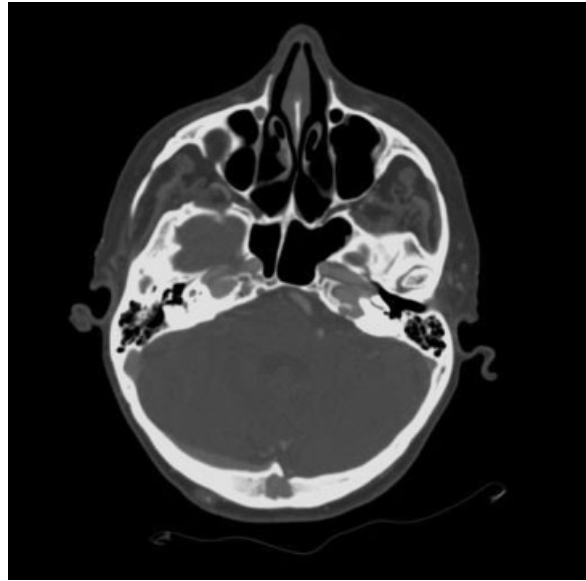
CT scan of the horizontal section of the petrous bone: Lytic images of the right and left petrous apices. There is a lacunar picture with peripheral osteosclerosis of the left petrous apex, located in front of the internal auditory meatus, inside the posterior part of the carotid canal without cortical osteolysis.
